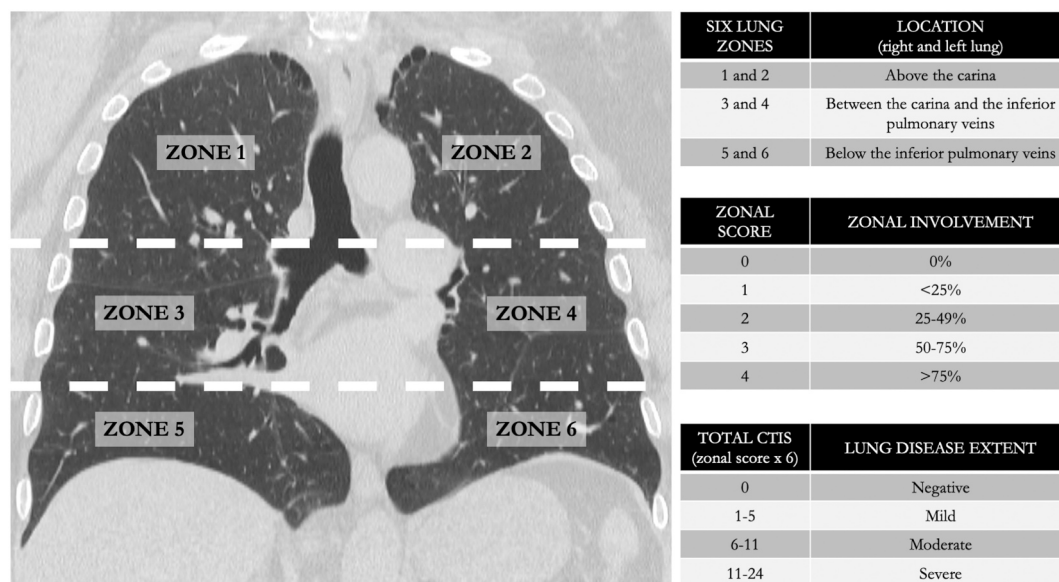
Scheme to assess the lung disease extent at HRCT according to the computed tomography involvement score (CTIS). The disease extent is estimated by dividing the lungs into six lung zones, scoring the lung involvement for each zone, and summing up all the zone scores. According to CTIS, HRCTs are classifiable as negative, or with mild, moderate, or severe lung disease extent.
